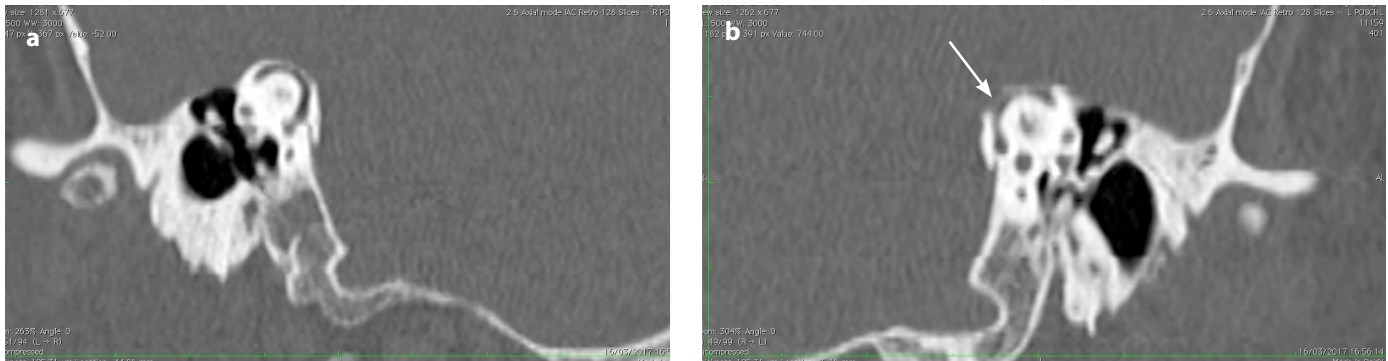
High-resolution computed tomography images of right (a) and left ear (b). Arrow points to dehiscence.
